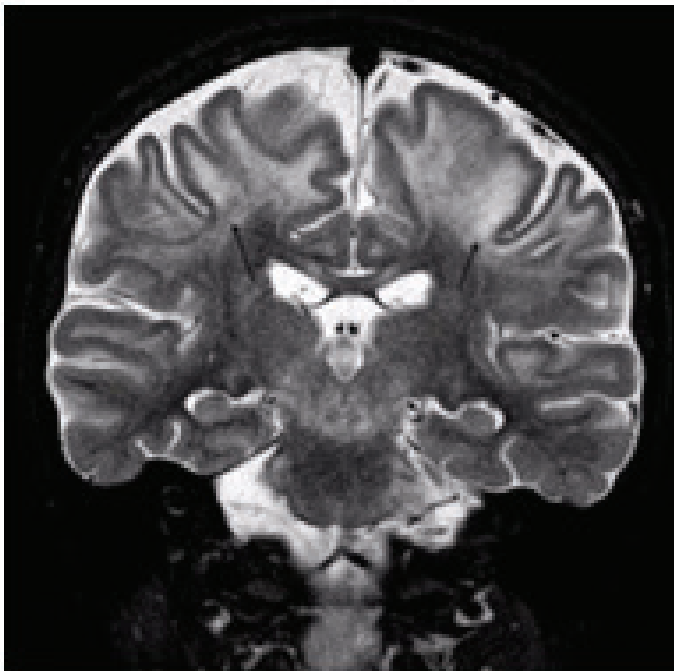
Coronal T2-weighted image demonstrating impairment of the subcortical white matter.
